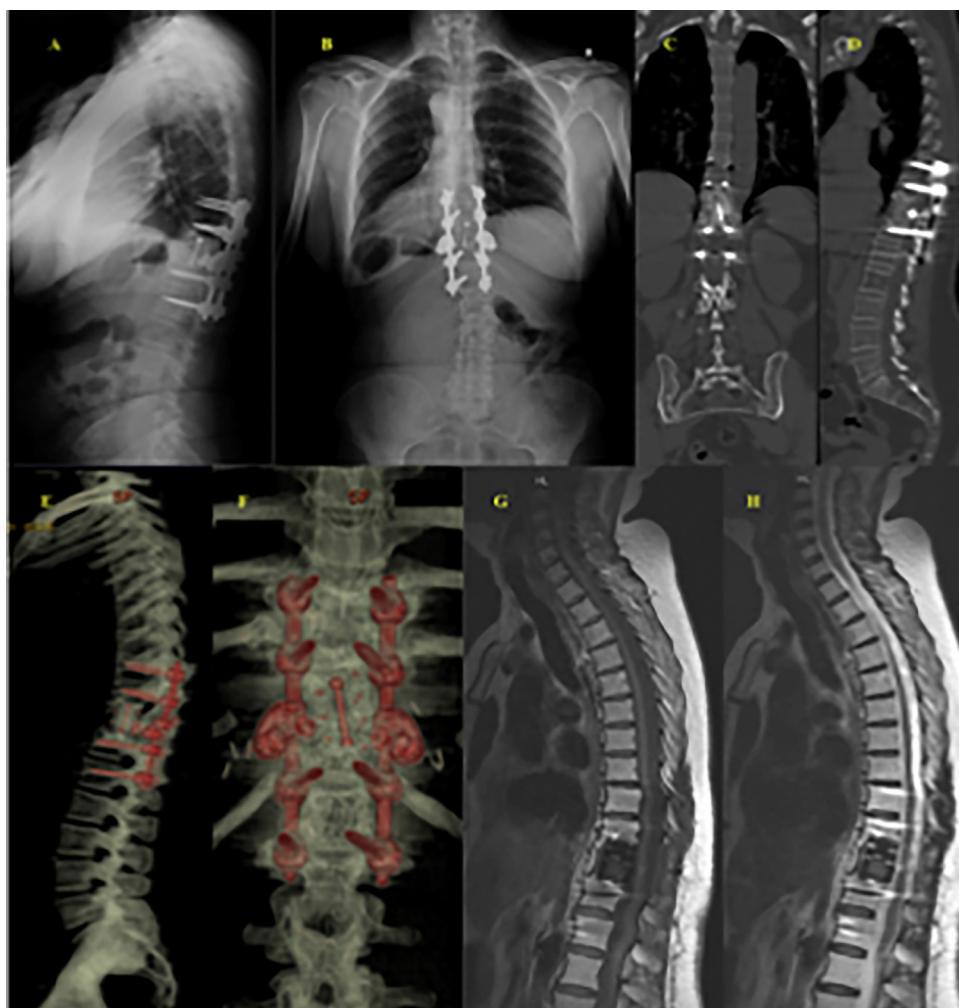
After 60 months of follow-up, an anteroposterior and lateral radiograph showing adequate coronal and sagittal balance (A, B). In the CT-body (C–F) and MR images studies (G, H), a free medullary canal without changes of local recurrence in the adjacent vertebral bodies, solid fusion and no distant lesions suggesting a primary lesion were observed.
